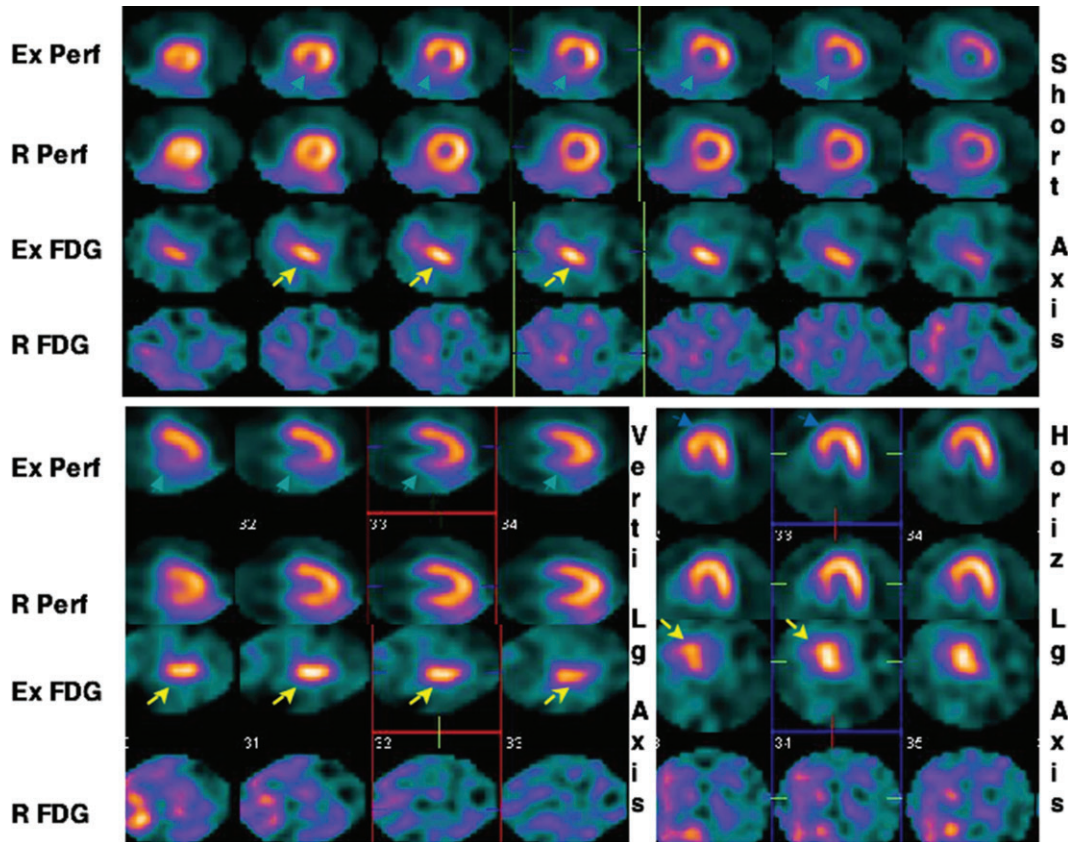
This 49-year-old male with exertional angina underwent exercise (Ex) and rest ^{99m}Tc -sestamibi (Perf) and ^{18}F -fluorodeoxyglucose (FDG) imaging 24 hours apart. Representative short axis, and vertical (Vert) and horizontal (Horiz) long (Lg) axes slices of the heart are shown. Reversible perfusion abnormality in the posterior septum and inferior walls is observed on this study. Intense FDG uptake on the exercise images (yellow arrows) is seen in the corresponding segments. No FDG uptake is seen in the heart on rest images. This patient was found to have 85% narrowing of the right coronary artery. Reproduced with permission from Dou et al.⁴⁰
